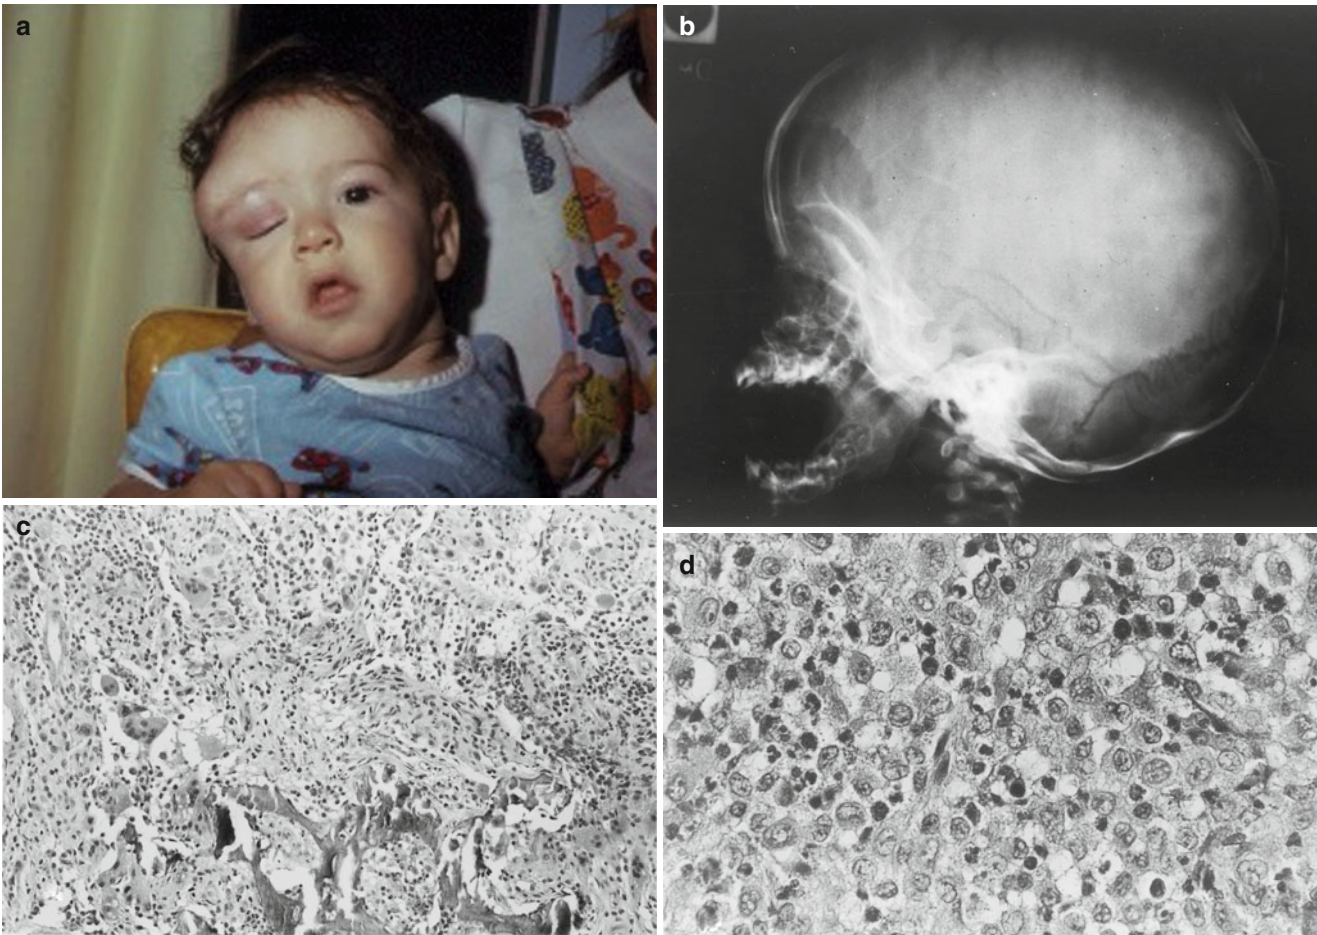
Langerhans cell histiocytosis. (a) Seven-month-old male with painful swelling, 3 × 3 cm, over the right orbital ridge noted 1 month prior to biopsy. The skull is one of the bones most commonly affected by this disease. (b) Skull radiograph, lateral view, reveals a lytic defect in the right frontal bone. Characteristically no reaction is present along the advancing margins of the lesion. (c) Cranial bone is
